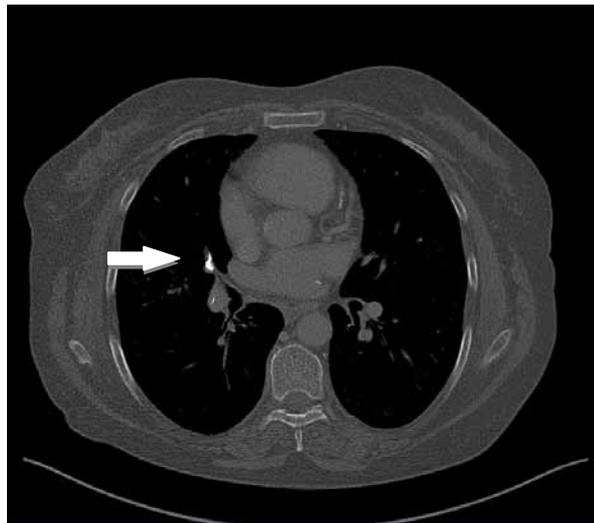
Native chest CT scan demonstrates a cement embolus in a peripheral right middle lobe pulmonary artery.
